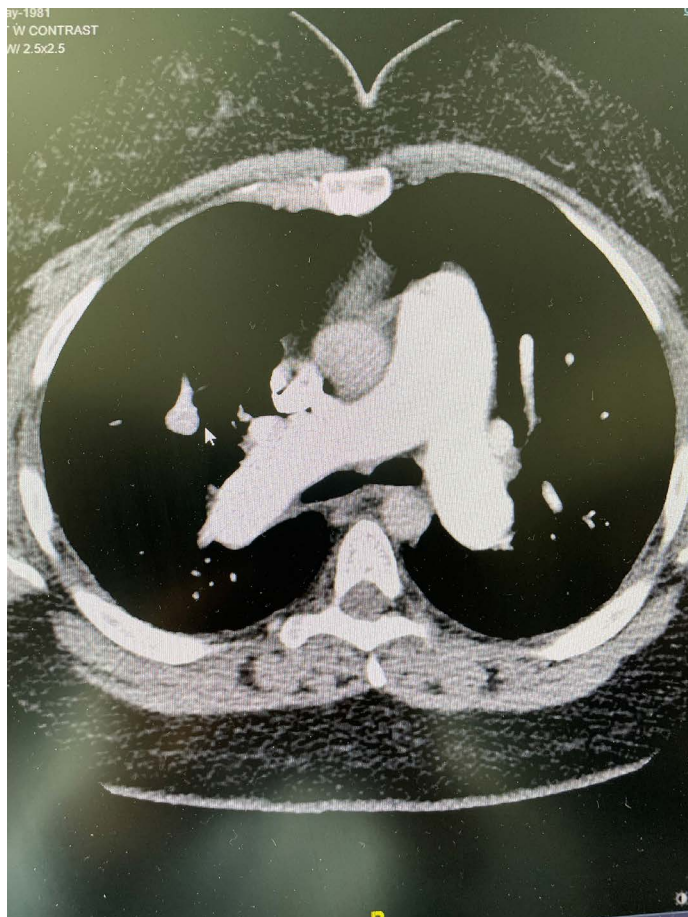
Partial anomalous pulmonary venous return (PAPVR) computed tomography (CT) chest.
